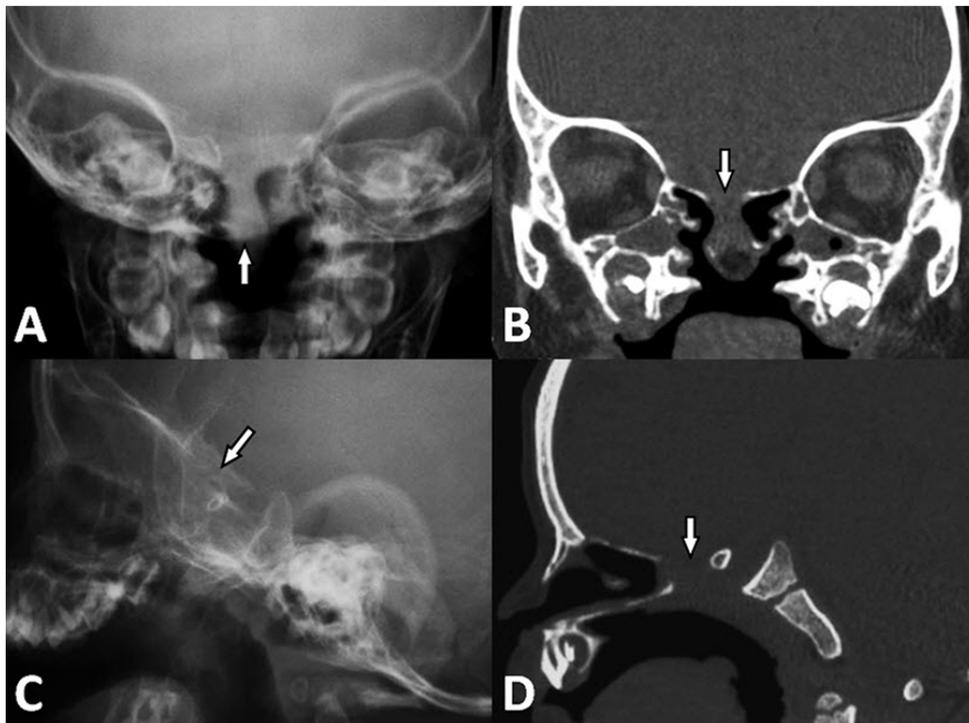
A) a frontal skull radiograph shows a soft tissue mass protrudes through the midline defect (arrow); B) a coronal CT of the head shows the defect in the body of the sphenoid bone (arrow); C) a lateral skull radiograph and D) a sagittal CT of the head show the defect at the body of the sphenoid bone (arrow).
